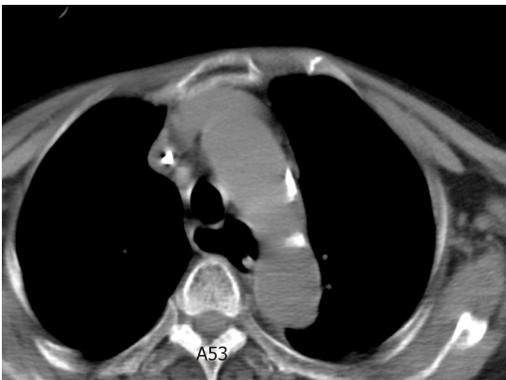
Postoperative chest computed tomography shows enlarged esophagus.
